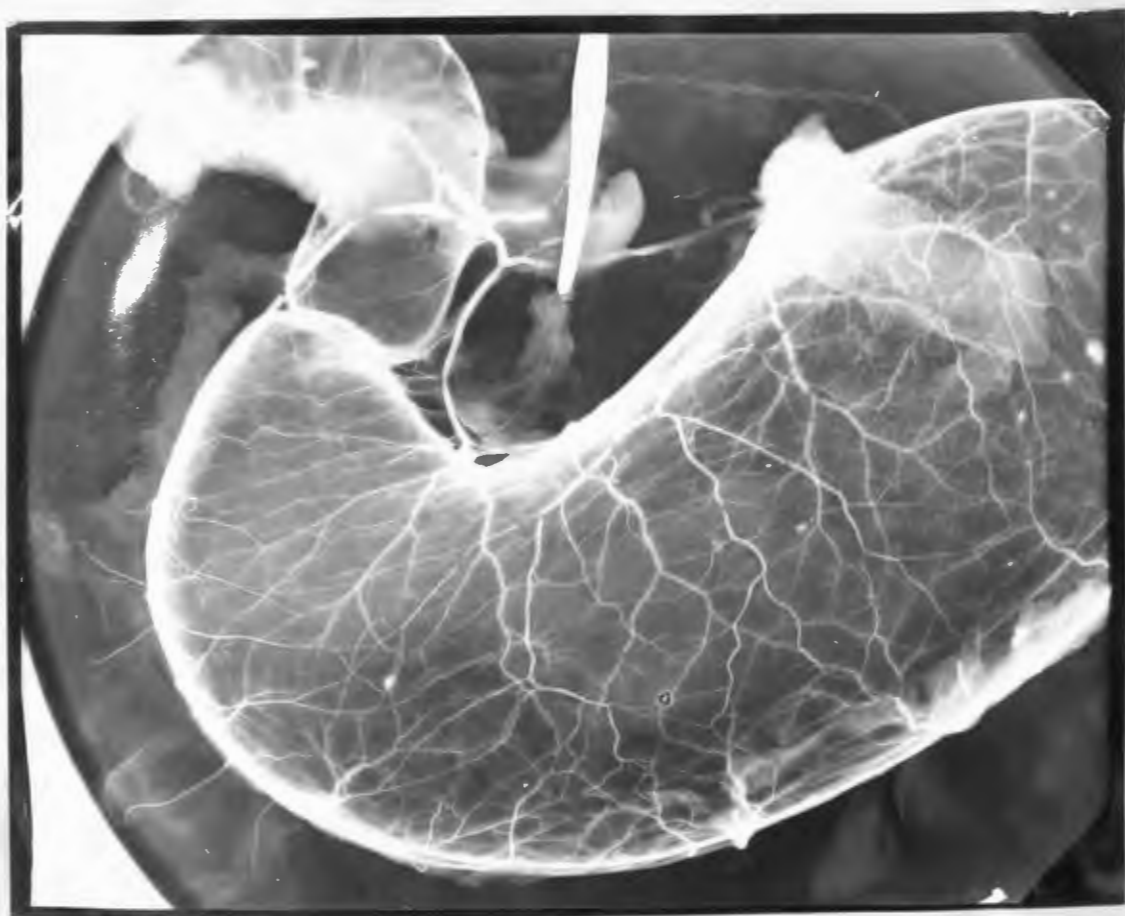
Stereoscopic radiograph. Vessels injected with gelatin bismuth solution.
